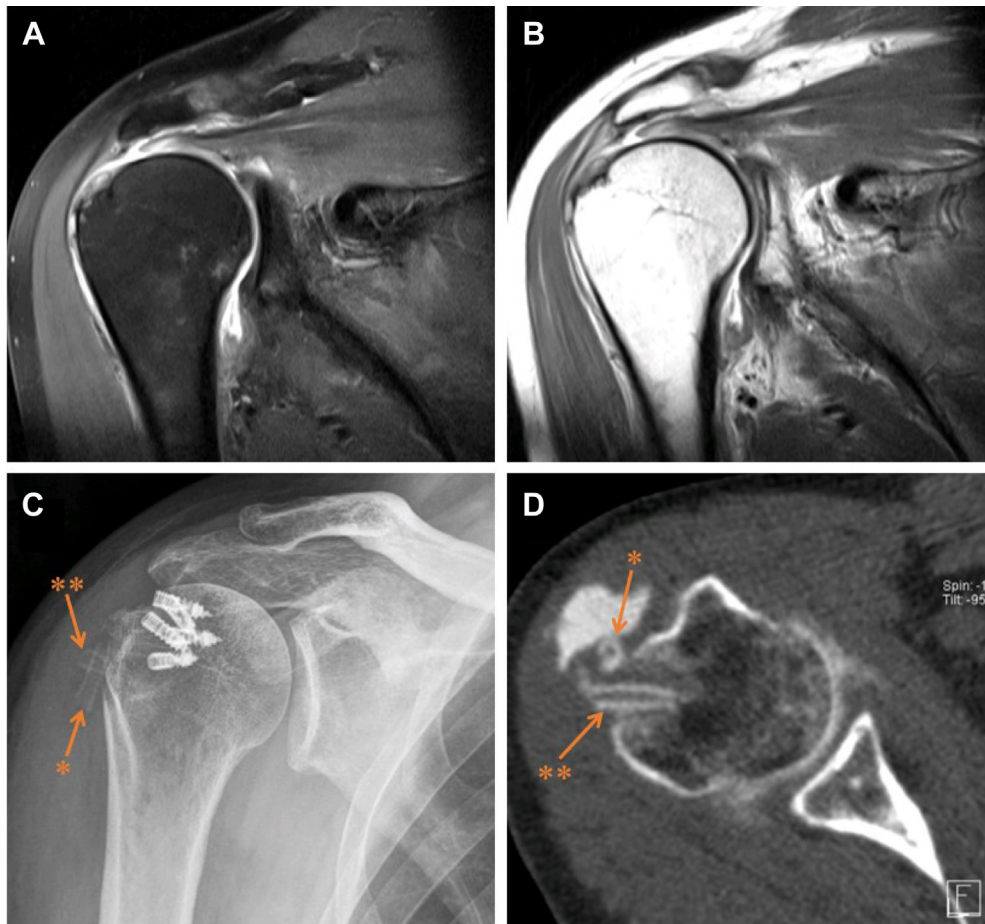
Rerupture of the rotator cuff repair occurred in 1 of 16 patients. (A, B) Preoperative paracoronal magnetic resonance imaging with transtendinous infraspinatus rupture and partial (superficial) supraspinatus rupture. (C, D) At 3 months postoperatively, a coronal radiograph and axial computed tomography scan show dislocation of 2 radiolucent lateral-row anchors with consecutive retears of the infraspinatus and posterior half of the supraspinatus tendon. *Fully dislocated anchor. Partially dislocated anchor.
